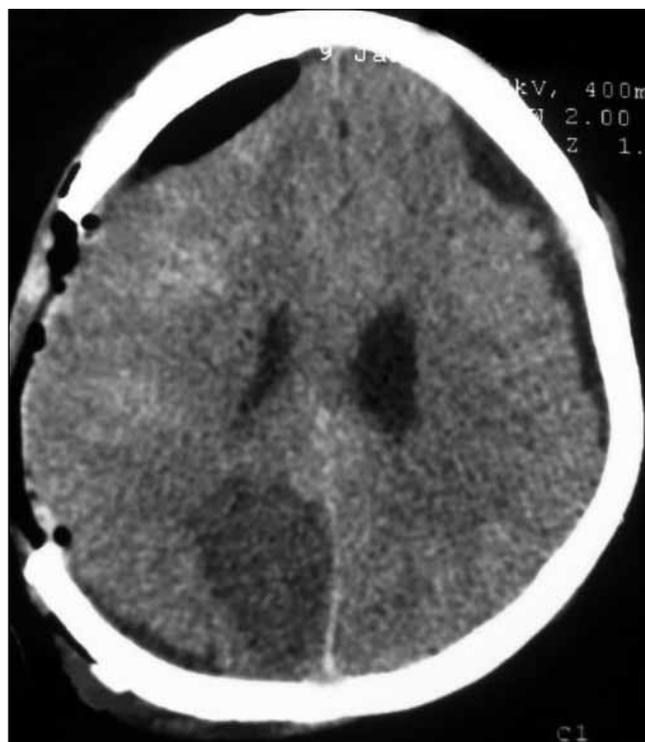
Axial CT scan shows craniotomy defect on right side with removal of acute SDH with obliterated surgical cavity with right posterior cerebral artery infarct.
